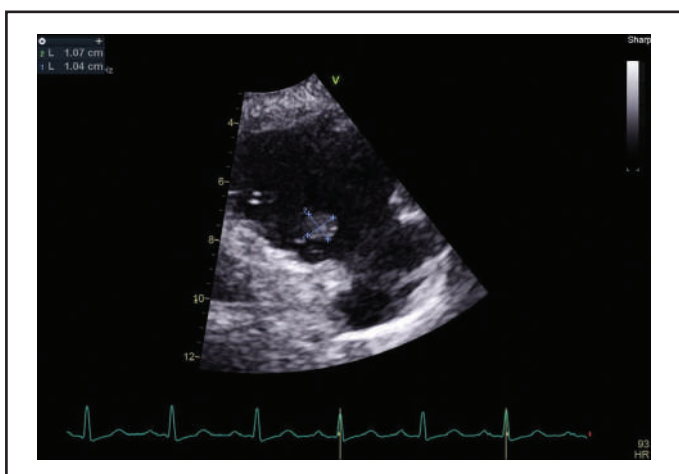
Right ventricular inflow view from the parasternal window demonstrating a mass on the tricuspid valve measuring 11 mm × 10 mm.
